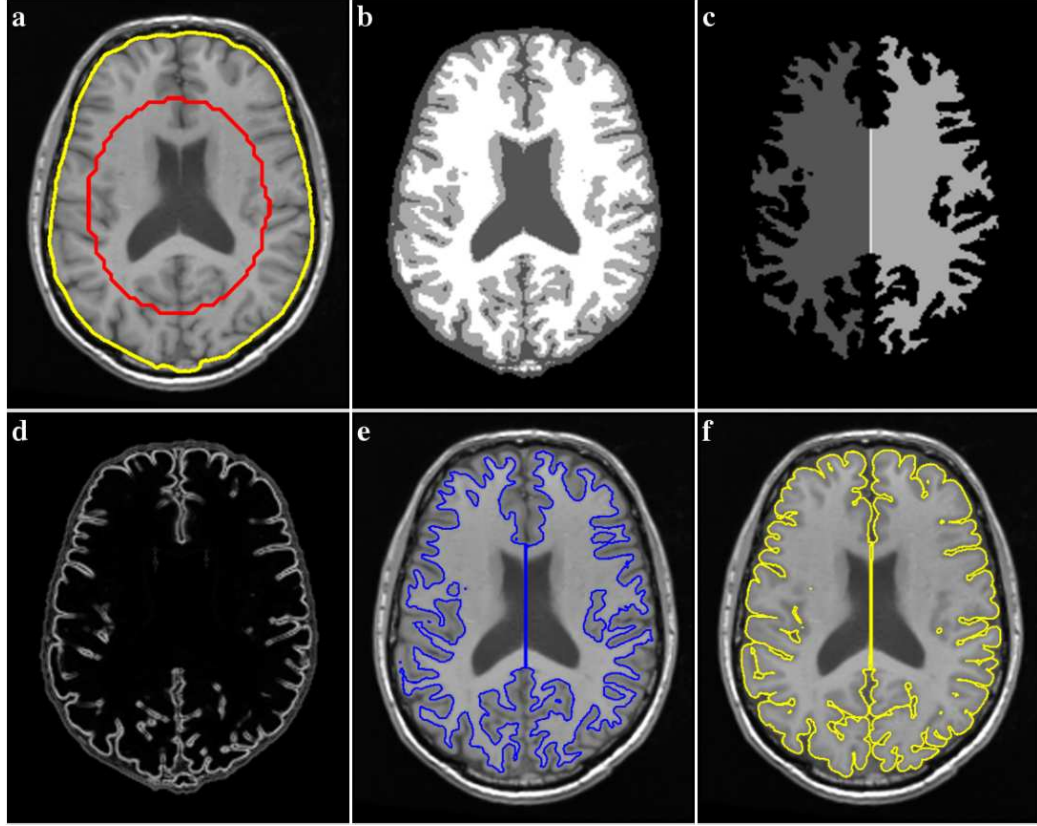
Extraction of the cortical boundaries. a) Spatially aligned MRI data with initial (red contour) and final (yellow contour) brain extraction contour superimposed. b) Brain tissue classified as WM, GM, and CSF. c) Ventricles and subcortical regions labelled as WM, and WM separated into hemispheres by a sagittal cut through corpus callosum. d) Edge map calculated from the fuzzy classifications. e) WM surface superimposed on the MRI data. f) GM surface superimposed on the MRI data.
